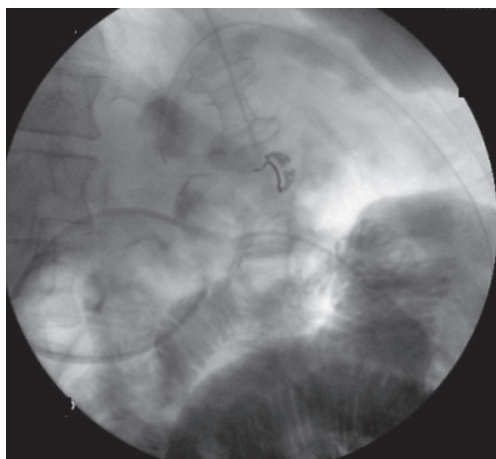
X-ray fluoroscopy showing stent in place from case 4.
